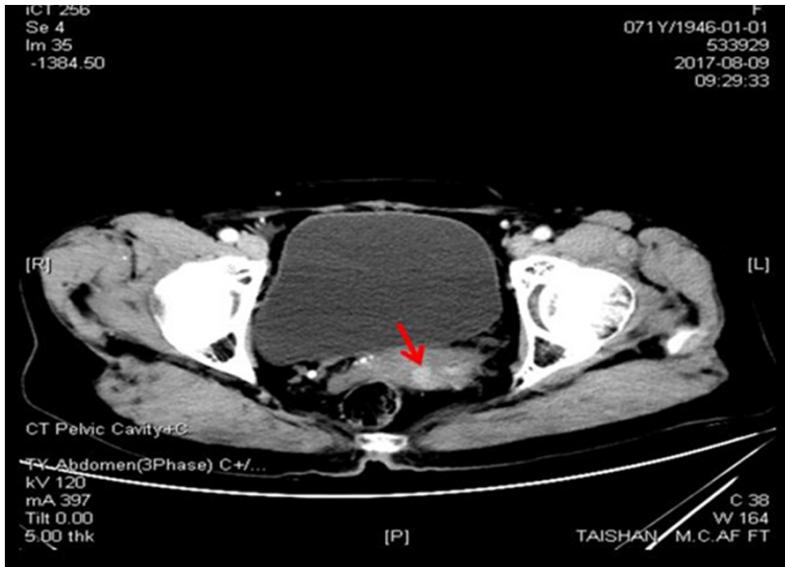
Pelvic cavity computed tomography demonstrated a well-demarcated mass (red arrows) in the uterine cervix.
